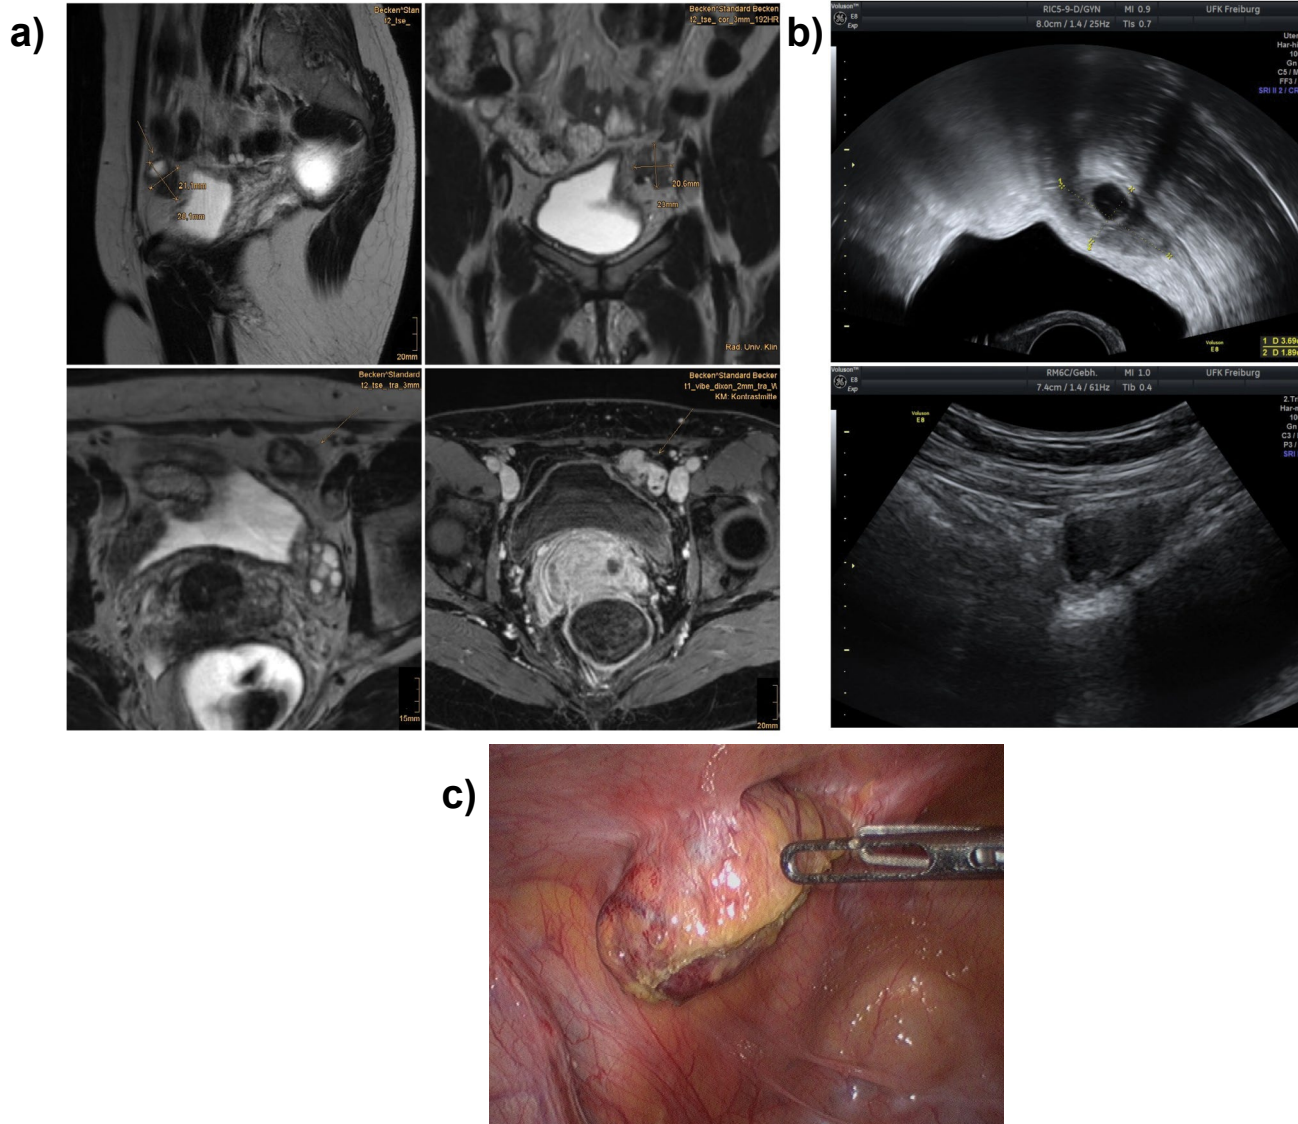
Case of a 43-year old patient with AWE left lateral of the bladder after laparoscopic supracervical hysterectomy (LASH) and cervicopexy. a) MRI of the pelvis, 1x multihance 15 ml (MU15): Endometrioma with a myomatous component left lateral of the bladder at the parietal peritoneum, 3.1x 3.0 cm, cystic. T1 hyperintense parts manifest contrast agent enhancement; b) Top: transvaginal ultrasonography (2D, Voluson E8 GE healthcare™, 5-9 Mhz); bottom: transabdominal ultrasonography (2D, Voluson E8 GE healthcare™); c) Intraoperative presentation of the endometrioma.
